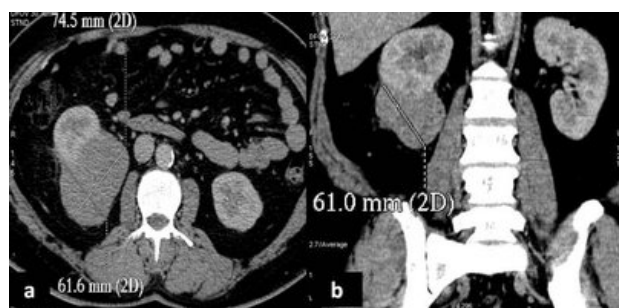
CT Scan image showing heterogeneously enhancing lesion in the right kidney measuring 74.5mm x 61.6mm x 61mm. A. Image showing transverse section; B. Image showing coronal section.
